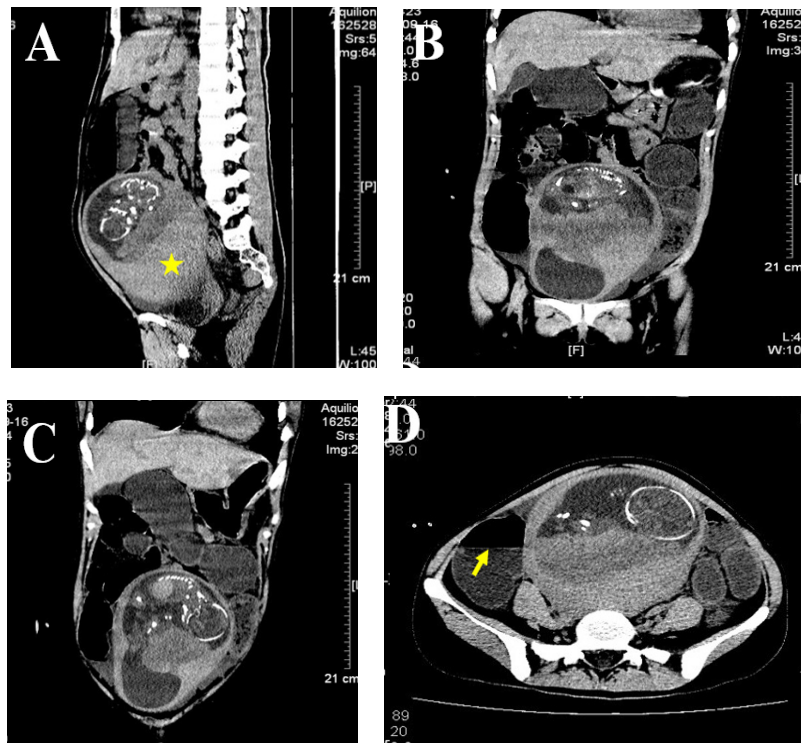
Computed tomography findings. A: Sagittal plane shows the thick posterior wall of the uterus (yellow star) and intestines above the site of obstruction are in the state of obstructive dilation and gas loading. B & C: Coronal planes show extremely dilated intestines with gas loading (yellow arrow) as well as peritoneal effusion. D: Transverse plane shows the thick posterior wall of the uterus and air fluid level (yellow arrow) indicating intestinal obstruction.
